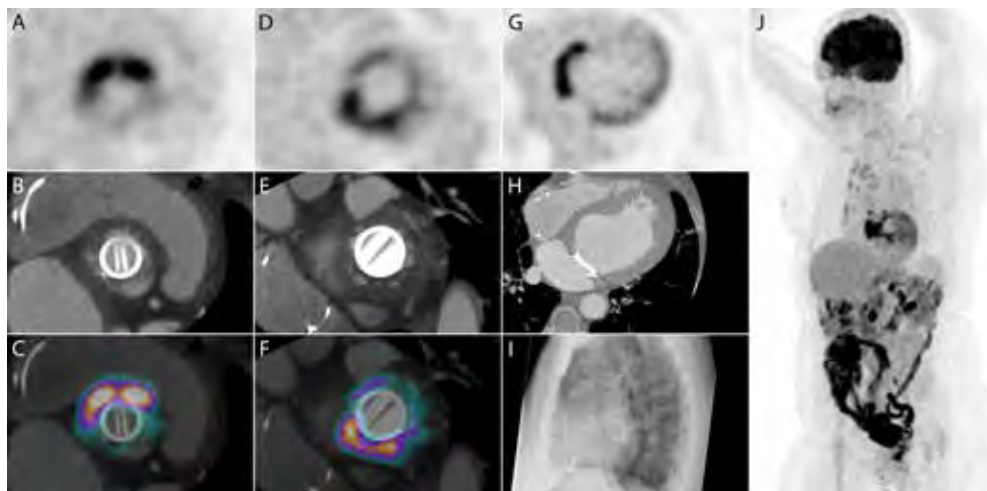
Infection versus inflammation. Images of a patient with both a prosthetic aortic and mitral valve, as well as two pacemaker wires in situ (plain X-ray, I). The PET, CTA and fused images (A-F) of the aortic (A-C) and mitral (D-F) valves showed increased FDG uptake near both valves, while PET and CTA images in the transaxial plane (G-H) showed that the entire basal septal wall between the valves was hyperactive. The minor uptake in the lateral wall is likely due to physiological myocardial FDG-uptake as a result of incomplete suppression. Finally, the MIP image (J) demonstrated the extent of pathological uptake. Combined, the images show a large metabolic lesion in the entire basal septum, reaching out to both PHVs. Blood cultures were negative, and inflammation parameters were relatively low for such a large lesion. Initial biopsy of the lesion was difficult to interpret, with suspicion of infection. However, antibiotics did not change the clinical presentation, and re-evaluation of the biopsy samples led to the diagnosis of a sterile granuloma, possibly sarcoidosis. Symptoms diminished under corticosteroid therapy.
